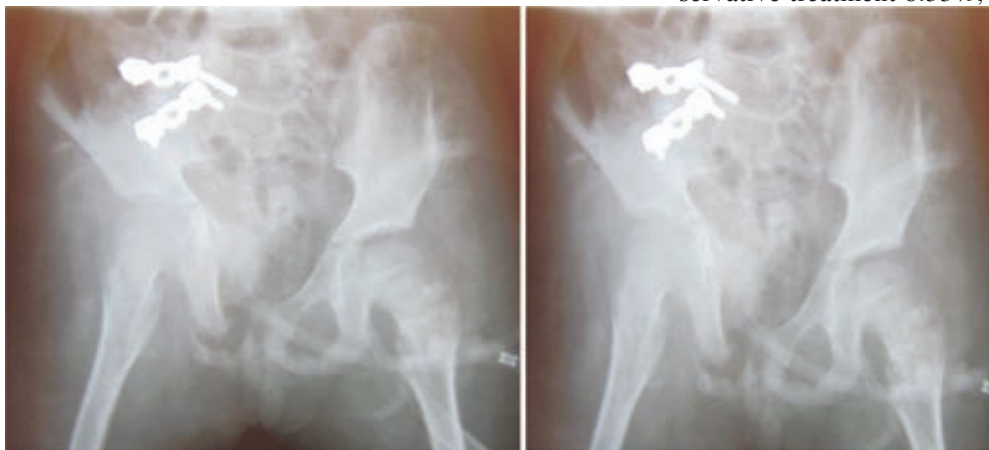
Postop X-ray control.
